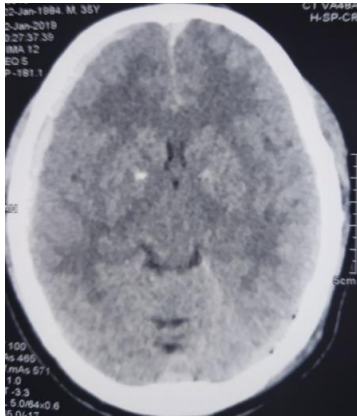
(A): CT scan at admission-shows right temporoparietal SDH.
